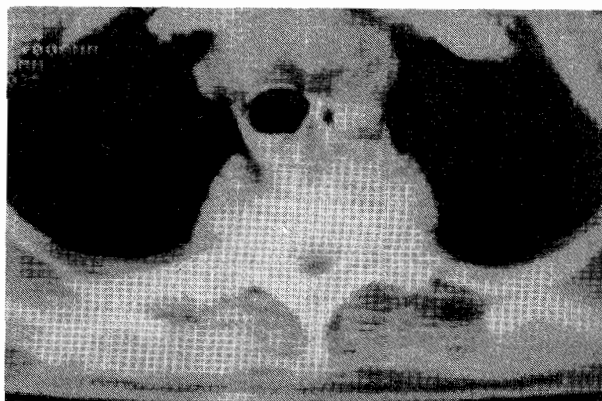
CT showing fragmented destruction with paravertebral soft tissue.
